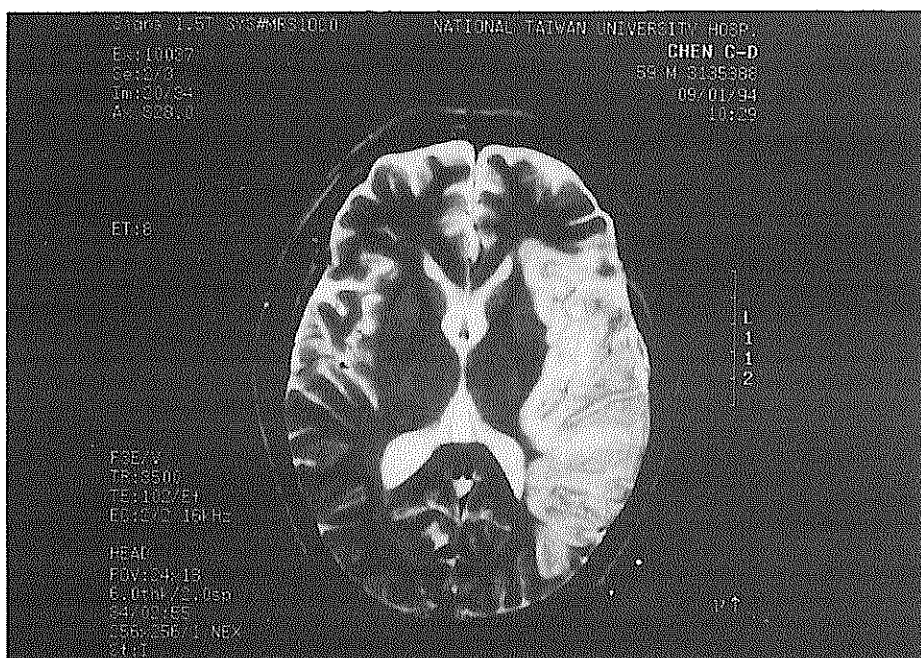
T2-weighted image of MRI of patient 2 nine days after onset: A single area of increased signal was found in the left frontotemporoparietal lobe.
